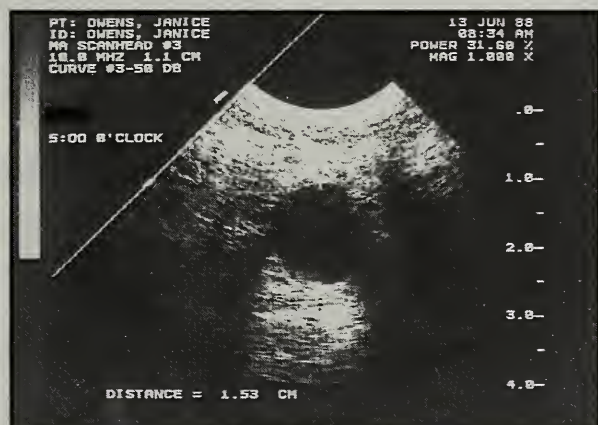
Ultrasound of cysts.
